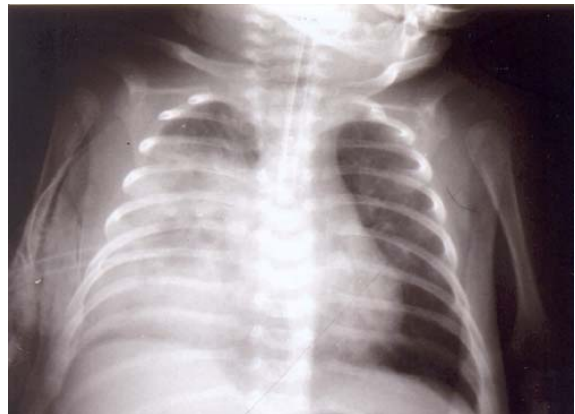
Chest radiograph on admission reveals large non-homogenous opacity and consolidation with ICD line of the right lung
